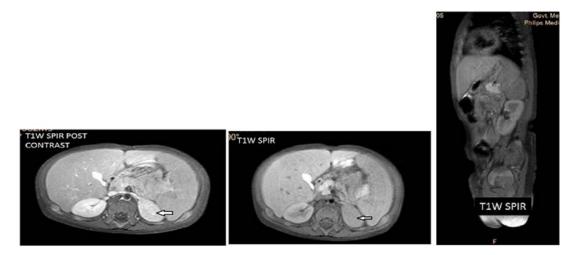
MRI showing tumor mass (arrow) with mixed signal intensity
